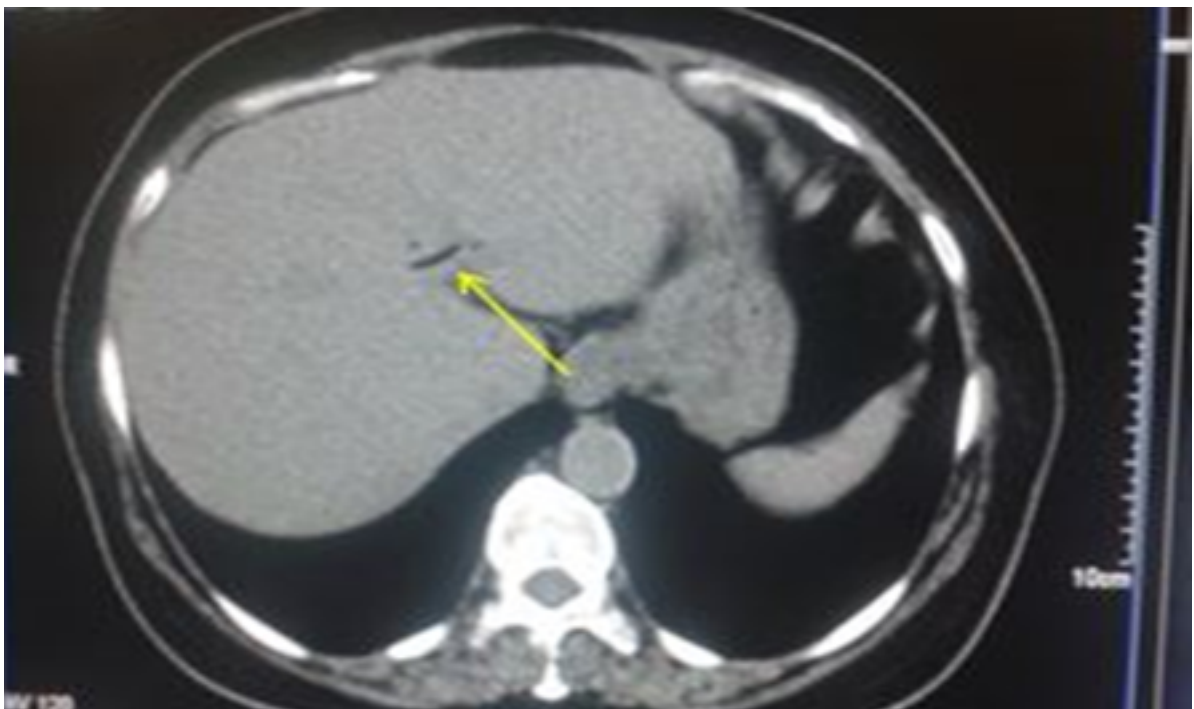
Axial section of plain abdominal CT shows air in the biliary tree.
